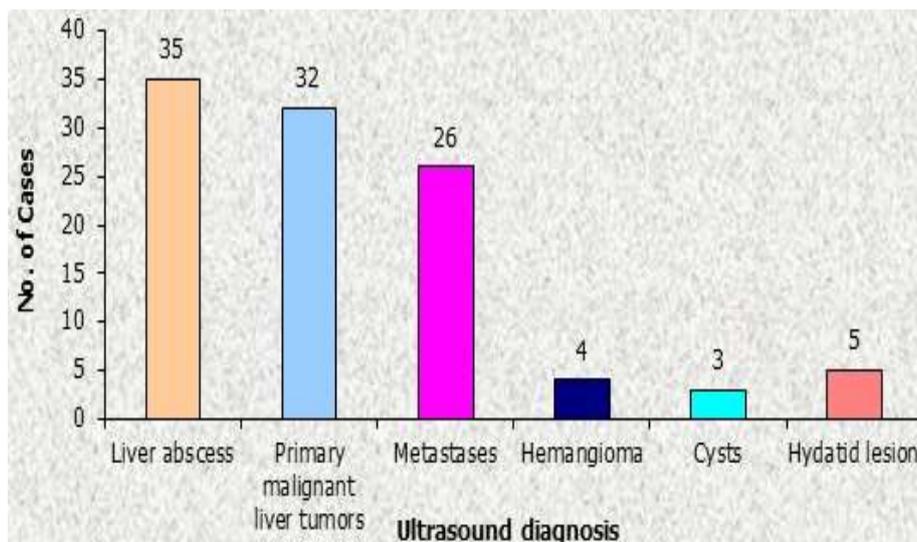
Distribution of cases diagnosed by ultrasonography
